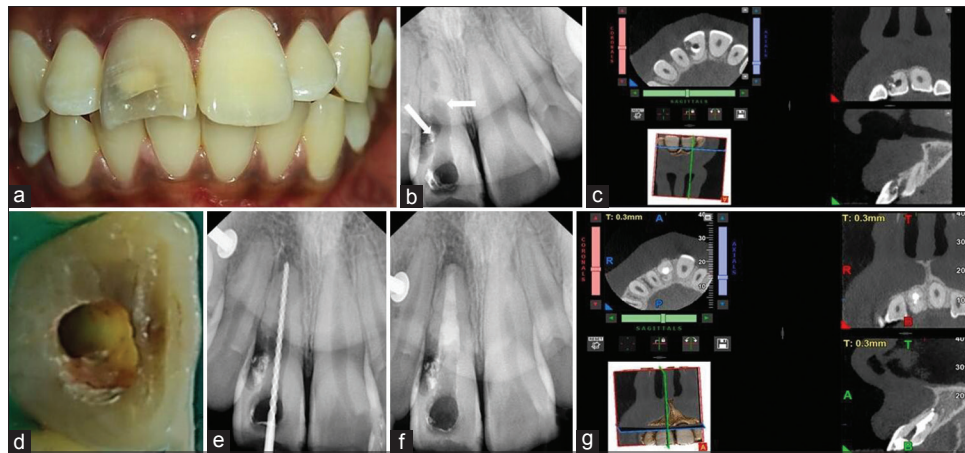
(a) Preoperative clinical view of the involved maxillary right permanent central incisor (b) Preoperative periapical radiographic view of the involved tooth with cervical radiolucency on the distal aspect (white arrow) and over the enlarged canal (white arrow) (c) Cone-beam computed tomography (CBCT) done for 3-dimensional assessment of the involved tooth and its surrounding structures (d) Clinical view of the refined lingual access opening under magnification. (e) Radiographic verification of the working length (f) Radiographic verification of the mineral trioxide aggregate (MTA) apical plug and monobloc obturation (g) CBCT view of the MTA-based radicular rehabilitation and reinforcement
